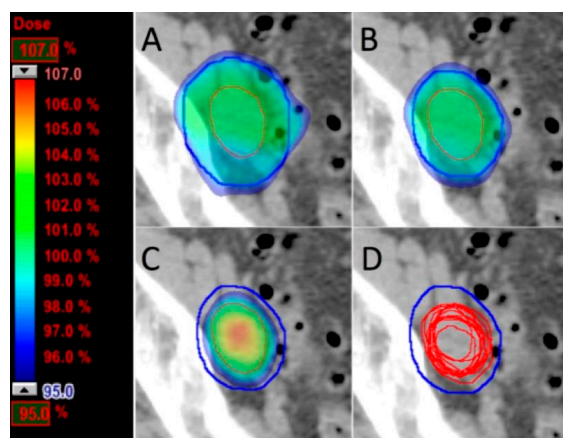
Pathological node (red contour) from locally advanced cervical cancer positioned at the external iliac vessels treated with a simultaneous integrated boost of 55 Gy/25 fx on top of whole pelvis 45 Gy/25 fx: A) Conventional planning 10 mm PTV margin (blue contour), B) Conventional planning 5 mm PTV margin, C) Coverage probability planning 5 mm PTV margin, D) Cone beam CT contours of the node obtained during treatment demonstrating regression towards the centre of the node.
